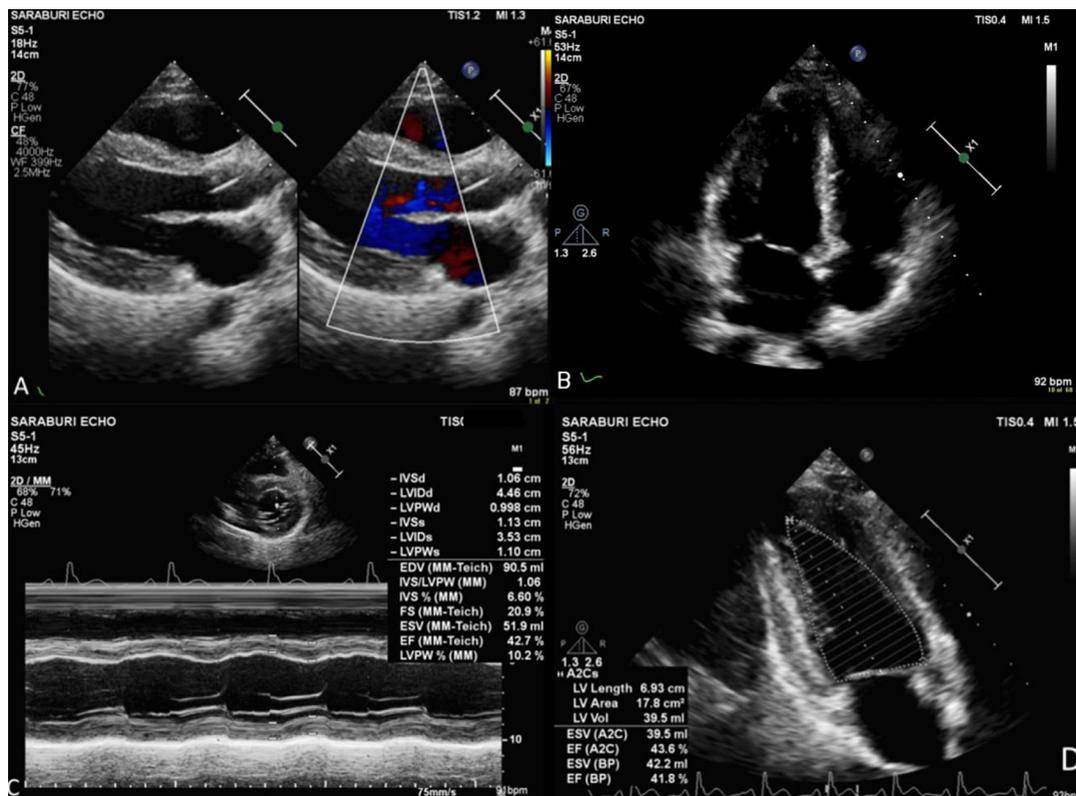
(A ,B, C, and D) Transthoracic echocardiogram (TTE) showed impaired LV systolic function, LVEF 42%, inferior hypokinesia without pericardial effusion.
